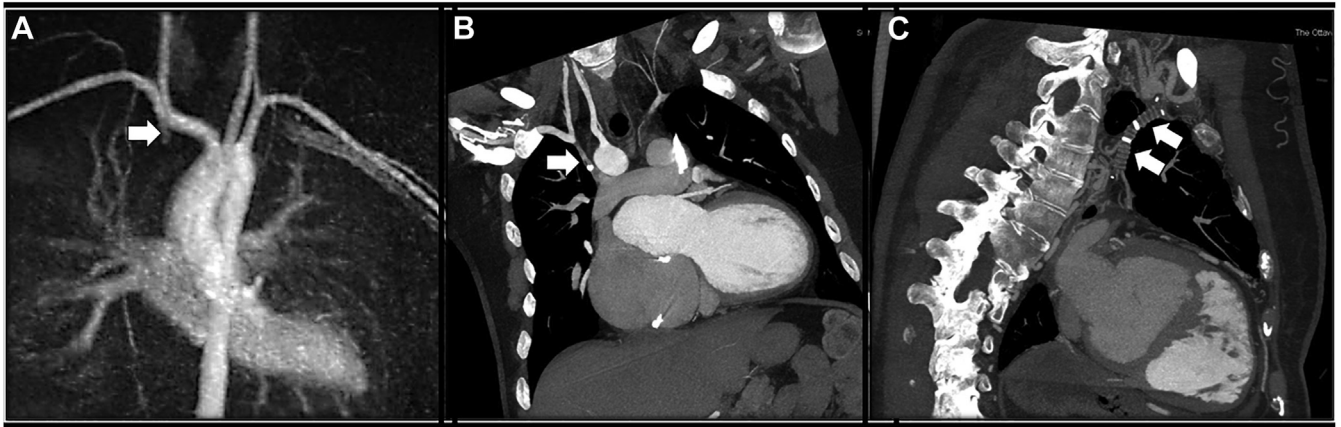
Variety of appearances of prior BTT shunts. (A) MR angiogram dynamic frame showing a vertical tiny vessel (arrow) descending from the left subclavian artery; this is all that remains of an otherwise occluded modified BTT shunt. (B) Coronal view from a cardiac CT showing this time the full length of an occluded BTT shunt running from the subclavian artery superiorly to the pulmonary artery inferiorly. (C) Nice example of an occluded BTT shunt on coronal oblique MIP from a CT angiogram. In this example, the ridges of the Gore-Tex material can be appreciated. BTT shunts used to be performed when a child was too young for total repair in infancy and then closed later when full repair was performed. In the current era, most patients will have a total repair in early life with no need for a shunt of this sort; however, the imaging physician will still encounter them in older adults—hence their demonstration here. BTT, Blalock-Thomas-Taussig; CT, computed tomography; MIP, maximum intensity projection.
